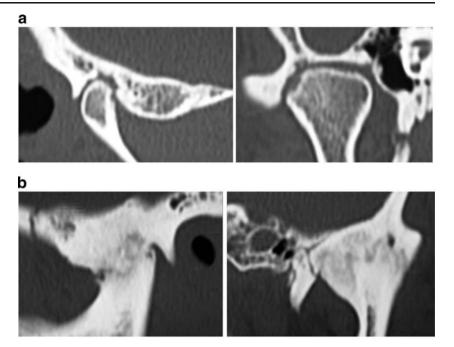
a CT images, bone window, showing erosion of the articular osseous components and mild bony formation on the anterior aspect of the right condyle. b CT images, bone window, displaying a roughly eroded condyle and mandibular fossa and bony ankylosis of the left TMJ
